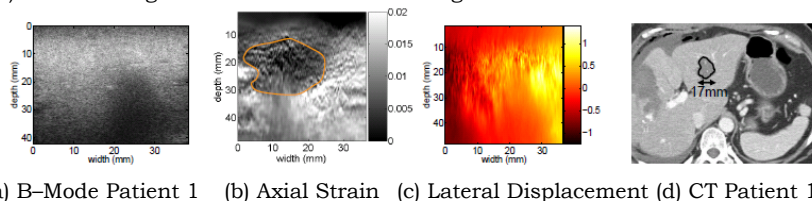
First patient trial of monitoring RF ablation using ultrasound elastography. The delineated lesion in the intra-operative strain image corresponds to the CT image which is obtained two weeks after the surgery.
